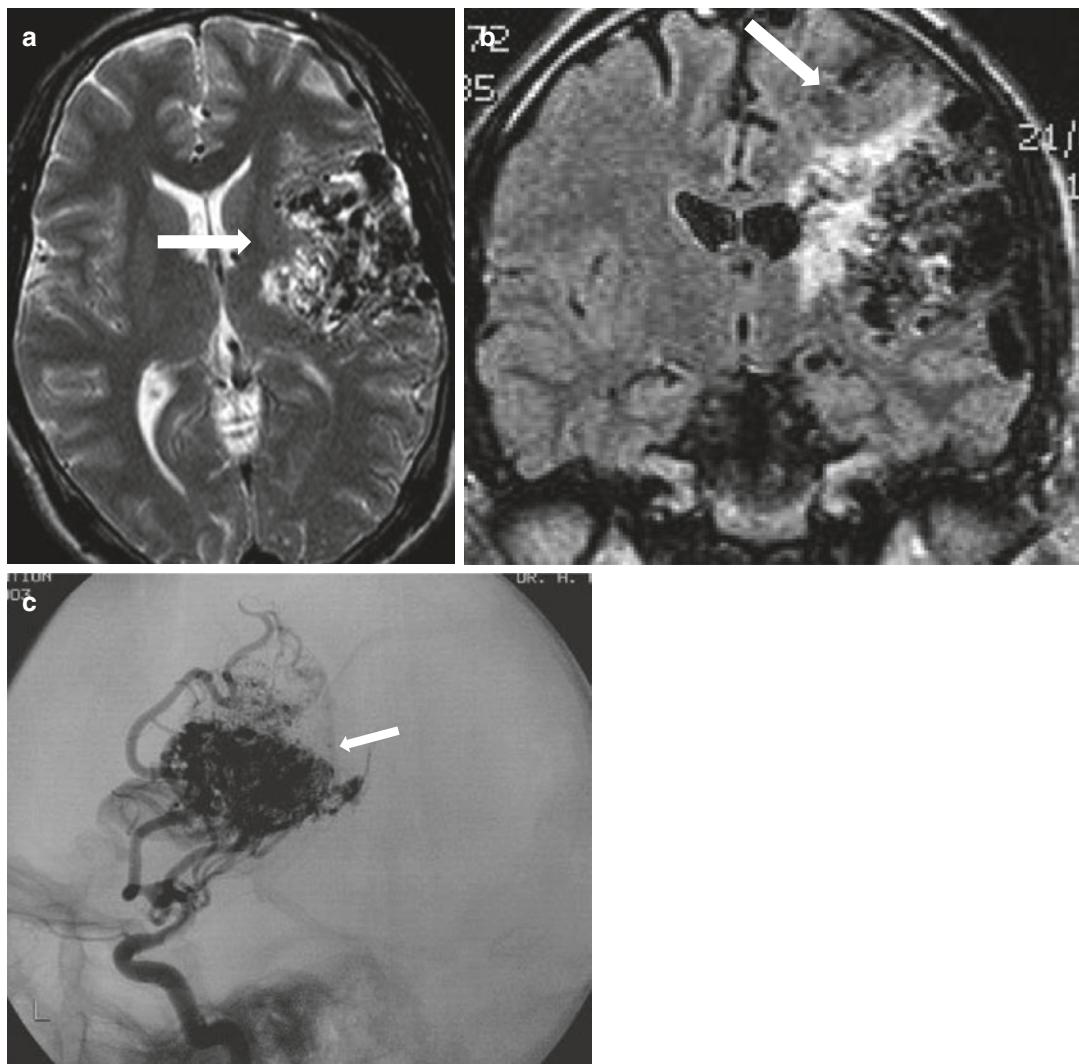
Gyral AVM. Axial T2-weighted MRI (a), sagittal T1-weighted MRI (b) and right internal carotid artery angiogram, lateral view (c) show a right temporal AVM (arrow)
